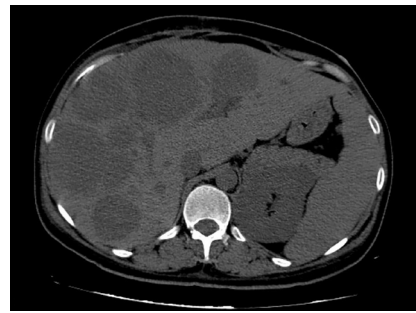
Abdominal Computed Tomography Demonstrating Multiple Well-Defined Hypervascular and Heterogeneously Enhanced Lesions up to 12.5 × 8.8 cm Throughout the Liver.
